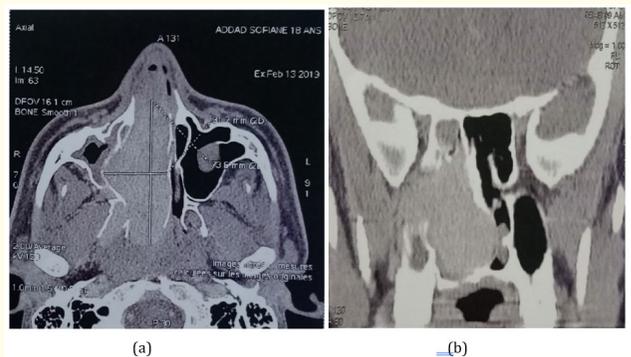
Periprocedural CT scan axial (a) and coronal (b) views showing invaded right medial pterygoid plate.
